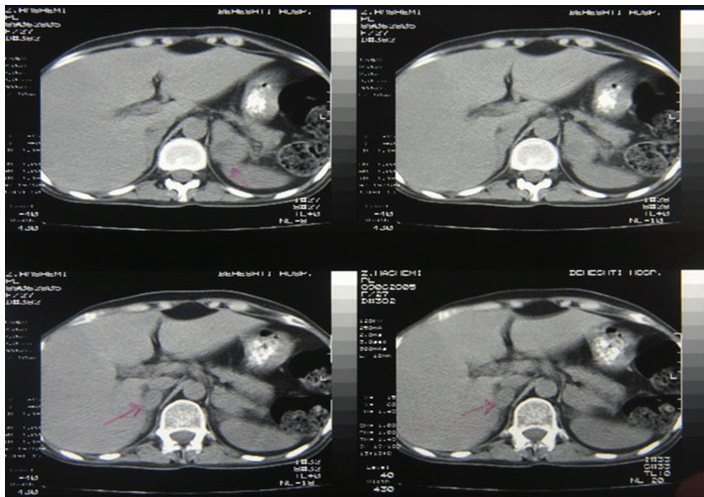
CT showing the bilateral adrenal enlargement with round masses in right and left adrenal.
